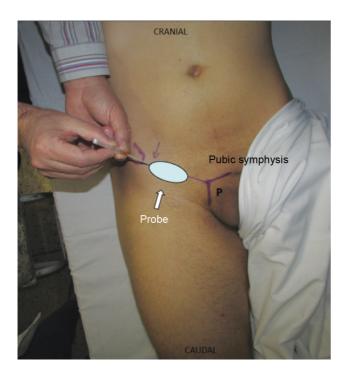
Aspect of the needle towards the apex of the demarcated iliopubic branch and positioning of the ultrasound probe.
